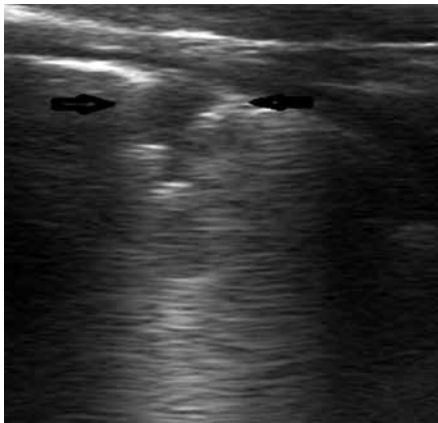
Small sub-centimetre sub-pleural consolidation (between arrows) in a child with suspected pneumonia who had a normal chest radiograph.
